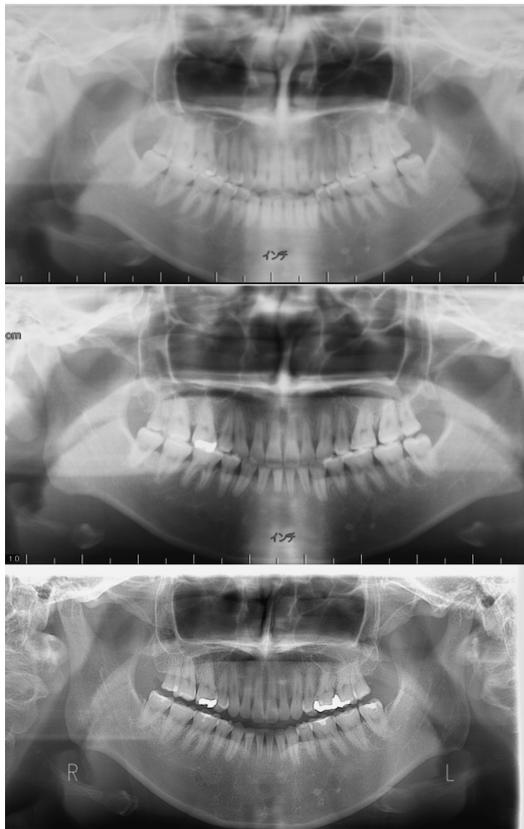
Panoramic radiographs. A: Before treatment (20 years and 11 months old); B: Post-active treatment (23 years and 3 months old); C: Post-retention (29 years and 1 months old)
